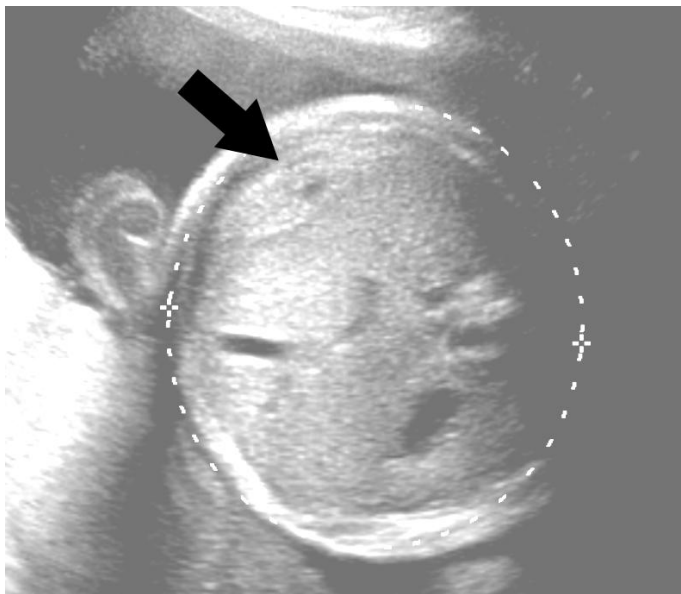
Ultrasound. 28 year old woman at 32 4/7 weeks gestational age underwent prenatal sonographic examination. Sonographic imaging (using 3.5 MHz transducer) demonstrates an ill-defined perihepatic region of inhomogeneous increased echogenicity (arrow) in the fetal abdomen.
